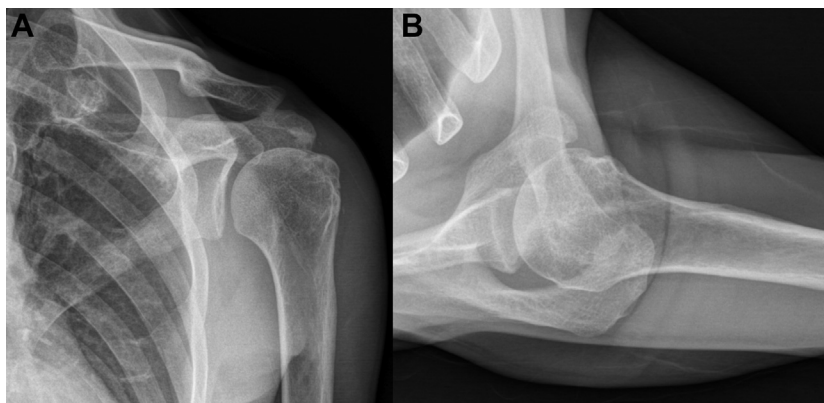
(A and B) Plain left shoulder true anteroposterior and transaxillary radiographs. The images show some degree of superior migration of the humeral head without glenohumeral joint osteoarthritis.
